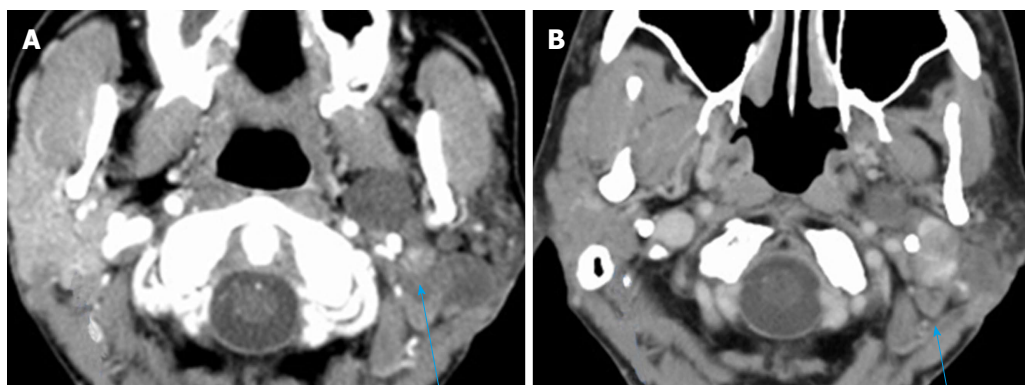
Axial computed tomography of the neck with contrast demonstrates oval shaped enhancing lesion of the left parotid gland deep to the left ramus of the mandible, centered at the left stylomandibular tunnel. A: The lesion measured 9 mm × 7 mm × 8 mm in 2007; B: The lesion measured 3.1 cm × 2.8 cm × 4.5 cm in 2015.
